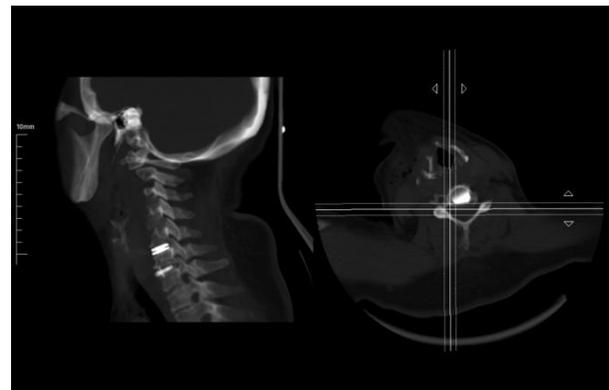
Sagittal foramen view in conventional CT
